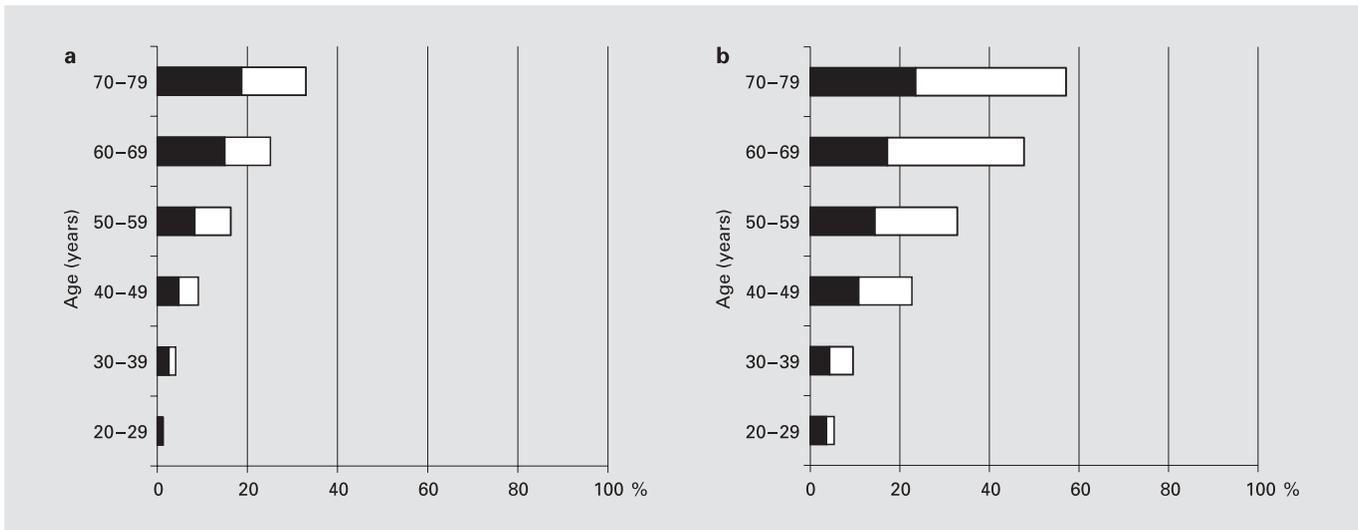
Age-stratified prevalence of sonographically diagnosed gallstones (■) and positive history of cholecystectomy (□) in the male (a) and female (b) population.
